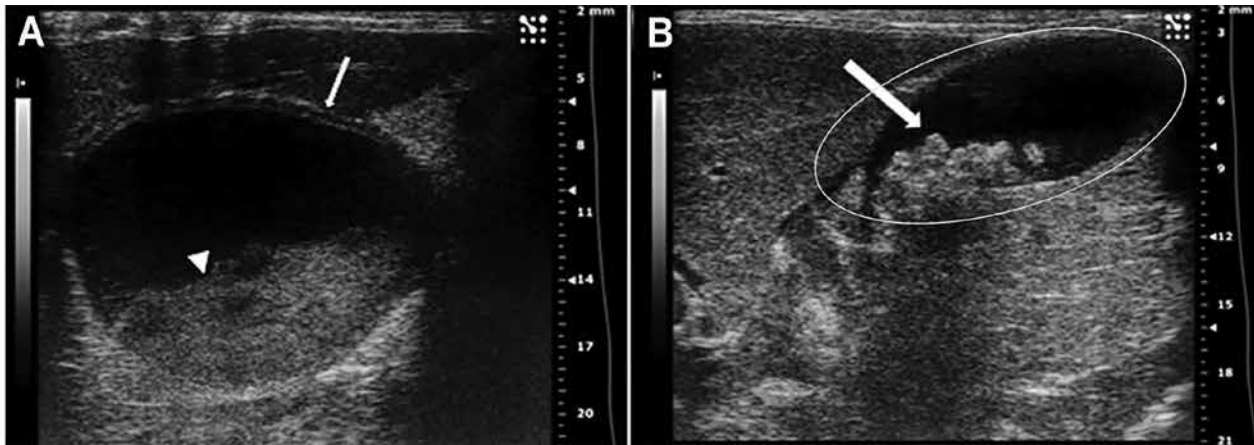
Abdominal ultrasonography. (A) Gallbladder contains echogenic material (arrowhead). A hypoechoic region within the gallbladder wall is suggestive of intramural edema (arrow). (B) The cystic duct (circle) is dilated with multiple echogenic, shadowing structures consistent with choleliths (arrow).
